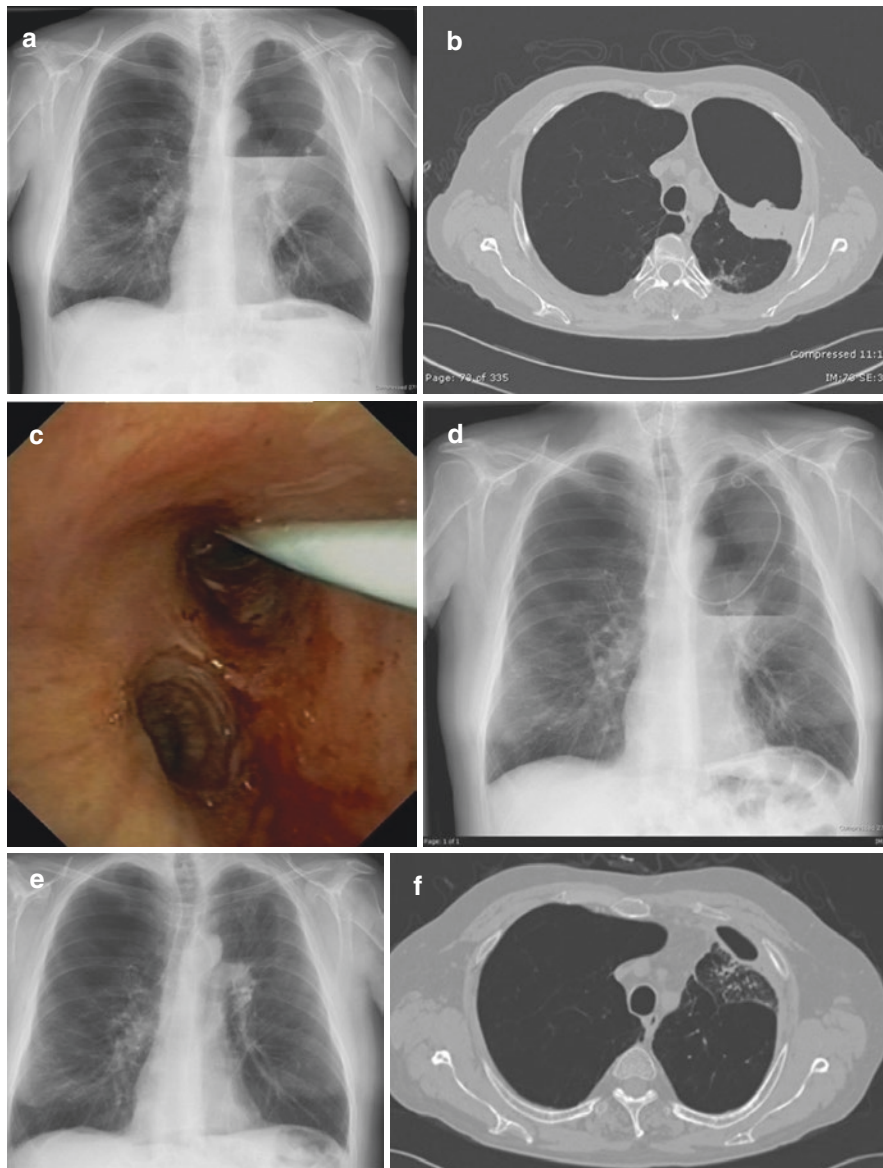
Lung abscess in left upper lobe (after 6 weeks of antibiotic therapy) (a). Corresponding CT from the same patient (b). Bronchoscopic image of the pigtail catheter entering the left upper lobe (c). Chest radiograph showing the pigtail catheter within the abscess cavity (d). Chest radiograph (e) and CT (f) 6 weeks after bronchoscopic drainage. (Reprinted with permission from Herth [147])
